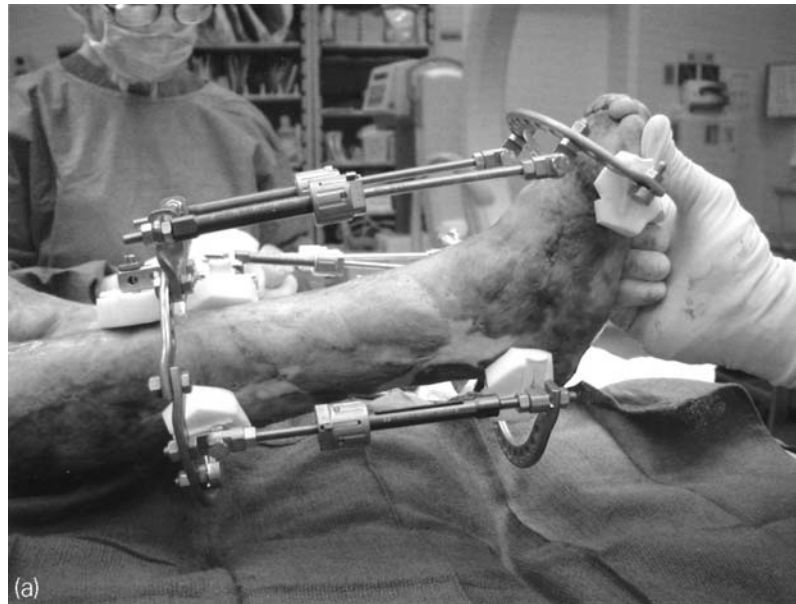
Thirteen-year-old girl who had a 97% TBSA burn in 1995. The burn injury caused bilateral deformities of the feet. Severe simple equinus (40 degrees) was present on the right foot and was treated with the hybrid apparatus described in Chapter 1 (Figure 1.14). (a) Intraoperative photograph of the apparatus. (b) Radiograph of the apparatus.
